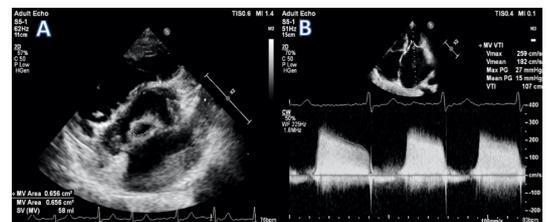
(A) Planimetry of mitral valve in the parasternal short axis view showing severe mitral stenosis. (B) Continuous wave Doppler across the mitral valve.
